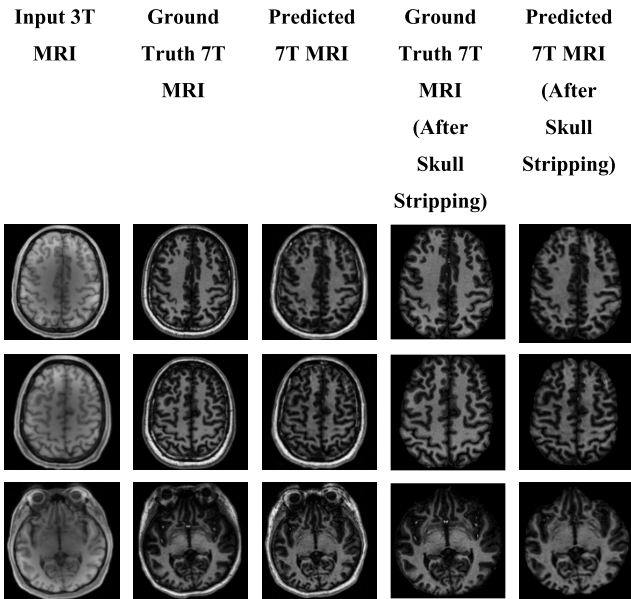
Predicted results by the best CycleGAN model for 3T to 7T MRI translation (before and after skull stripping).
